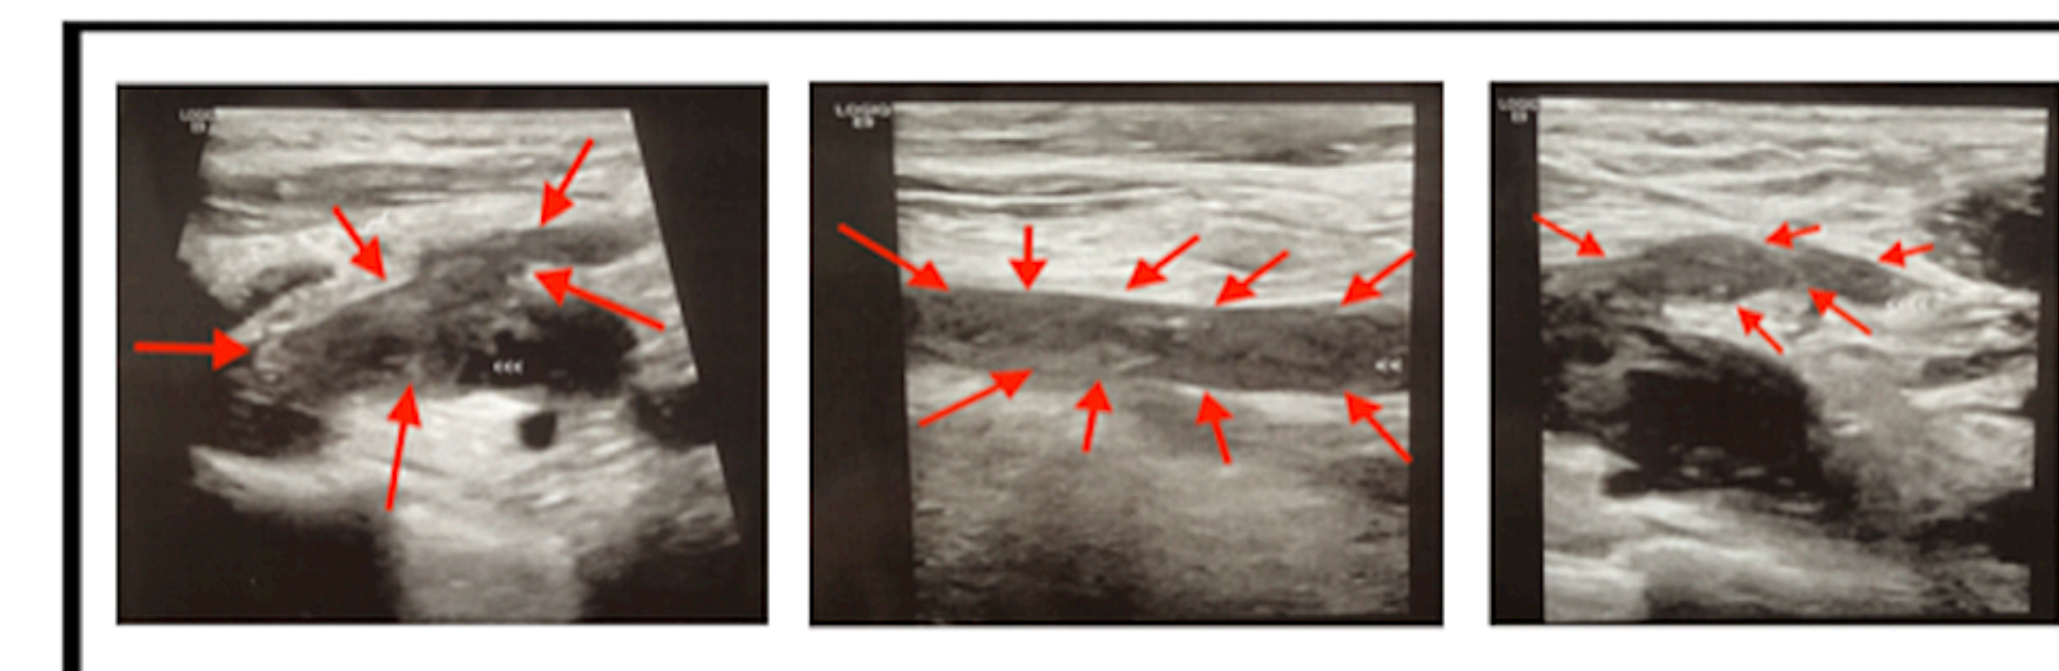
Ultrasound of bilateral lower extremities by Gray scale Doppler with color flow spectral broadening. These demonstrate extensive bilateral deep venous thrombosis.
